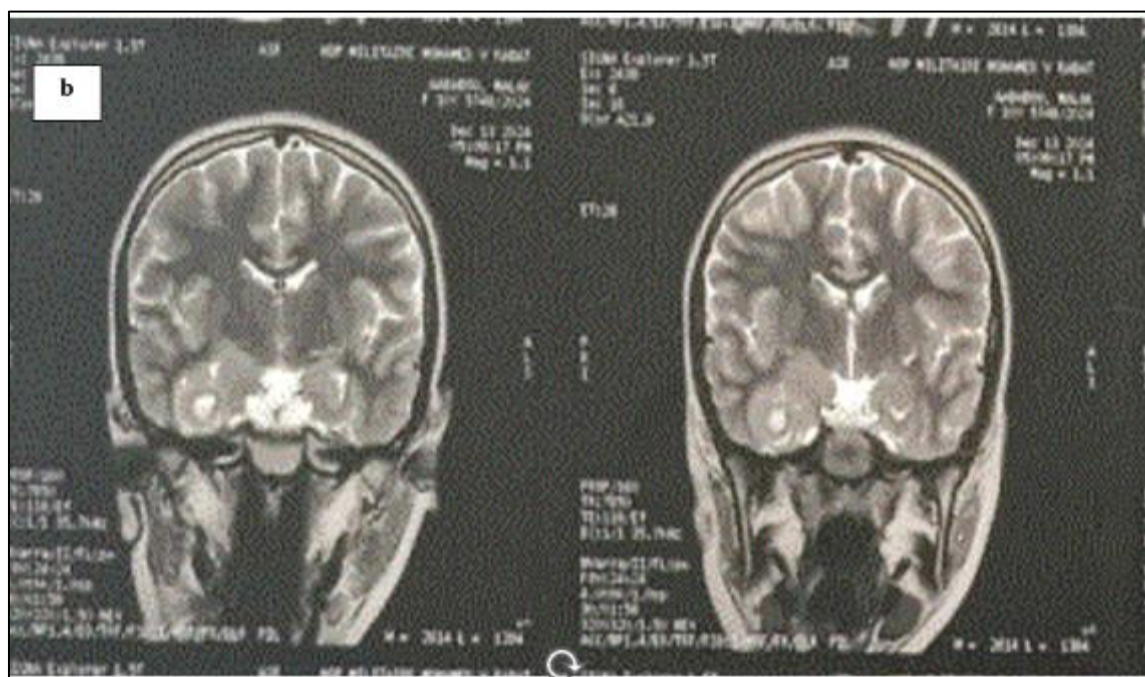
Transverse (a) and sagittal (b) brain MRI showing a well-defined, rounded, heterogeneous intra-axial lesion in the right temporal cortex, hypointense on T1-weighted images and hyperintense on T2/FLAIR
